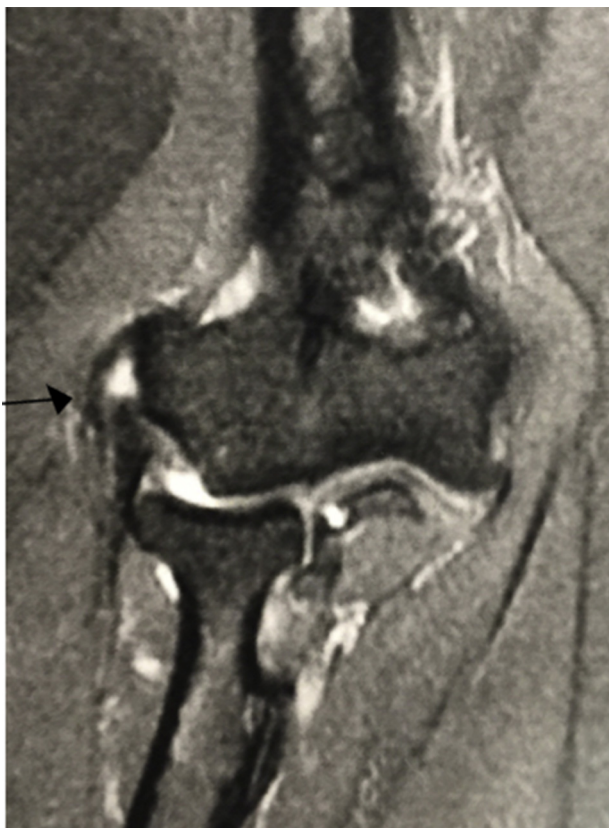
Magnetic resonance imaging showing common extensor tendon lesion (arrow).
